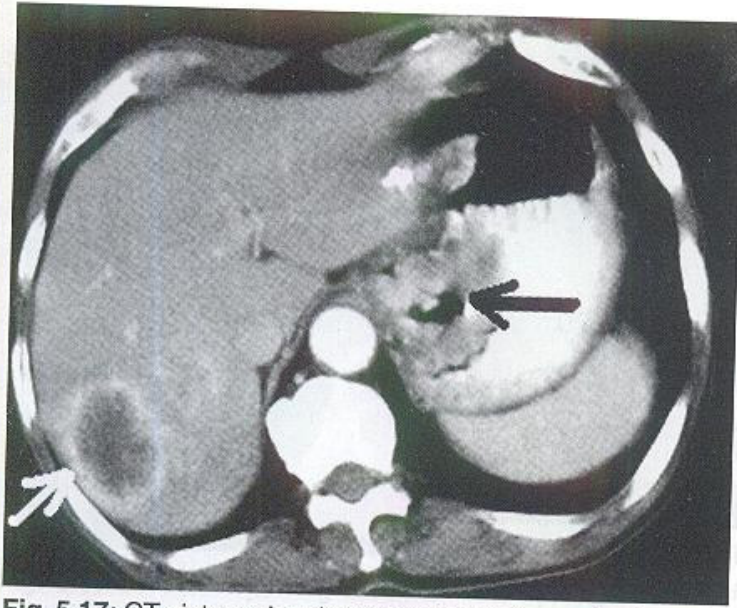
CT picture showing primary carcinoma in stomach with secondaries in liver. Note the thickening of the wall of the stomach with mucosal irregularity.
